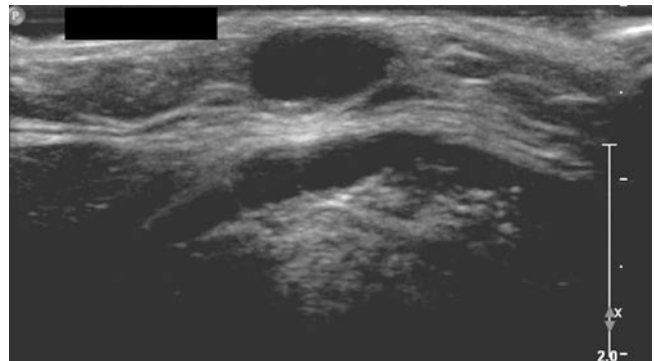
Thyroglossal duct cyst. Transverse ultrasound image of the neck shows an ovoid anechoic structure to the right of the midline
